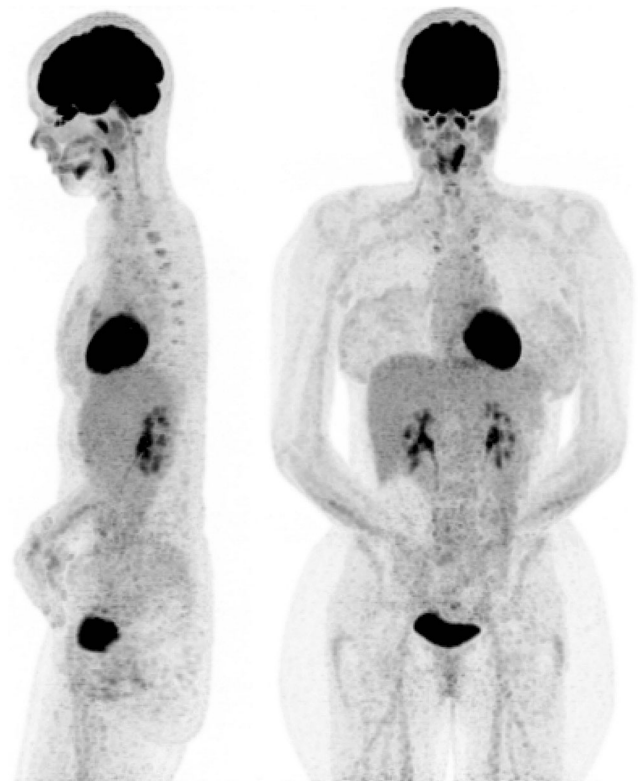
Whole-body FDG PET/MRI follow-up scan of a patient with former multiple myeloma, showing spontaneous FDG accumulation in the heart
